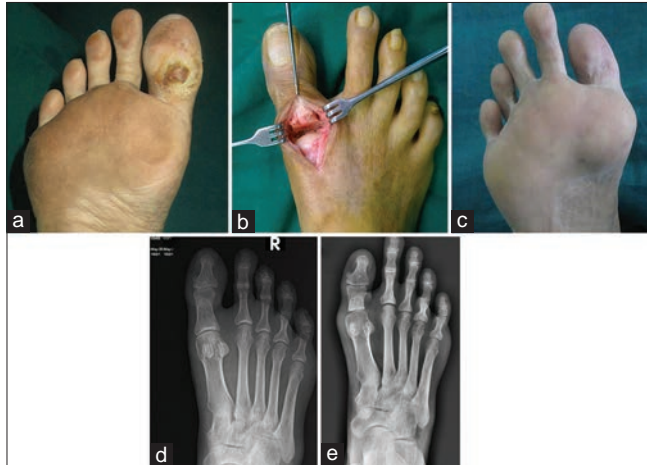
Keller arthroplasty for plantar hallux interphalangeal ulcers. (a) Plantar hallux interphalangeal joint ulcer. (b) The proximal third of the proximal phalanx of the great toe is removed through a dorsal incision. (c) It results in a slightly shortened but mobile and ulcer free digit. (d) Pre- and (e) Post-operative X-rays of the same patient showing the extent of bone resection of the base of the proximal phalanx of the great toe
